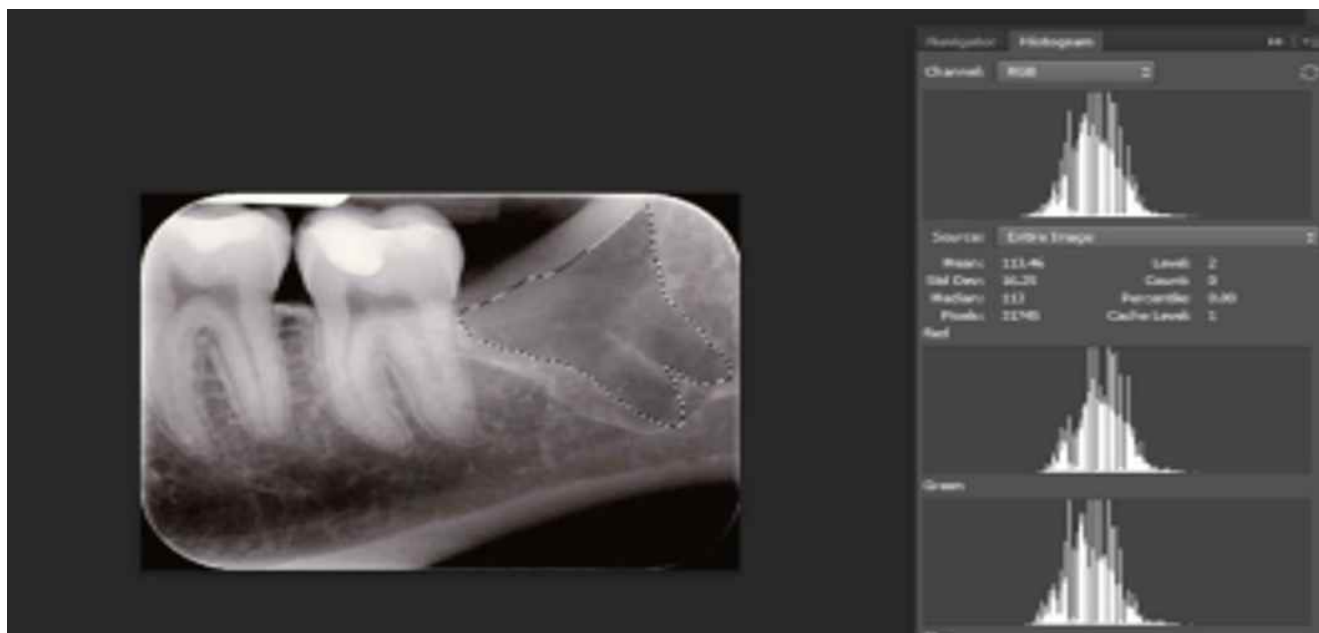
Assessment of digitalized intra-oral peri-apical radiograph using Adobe Photoshop CS6 for gray-scale histographic values. Dotted line points to a marked area being measured and the histogram shows the mean gray-scale value of the marked area
